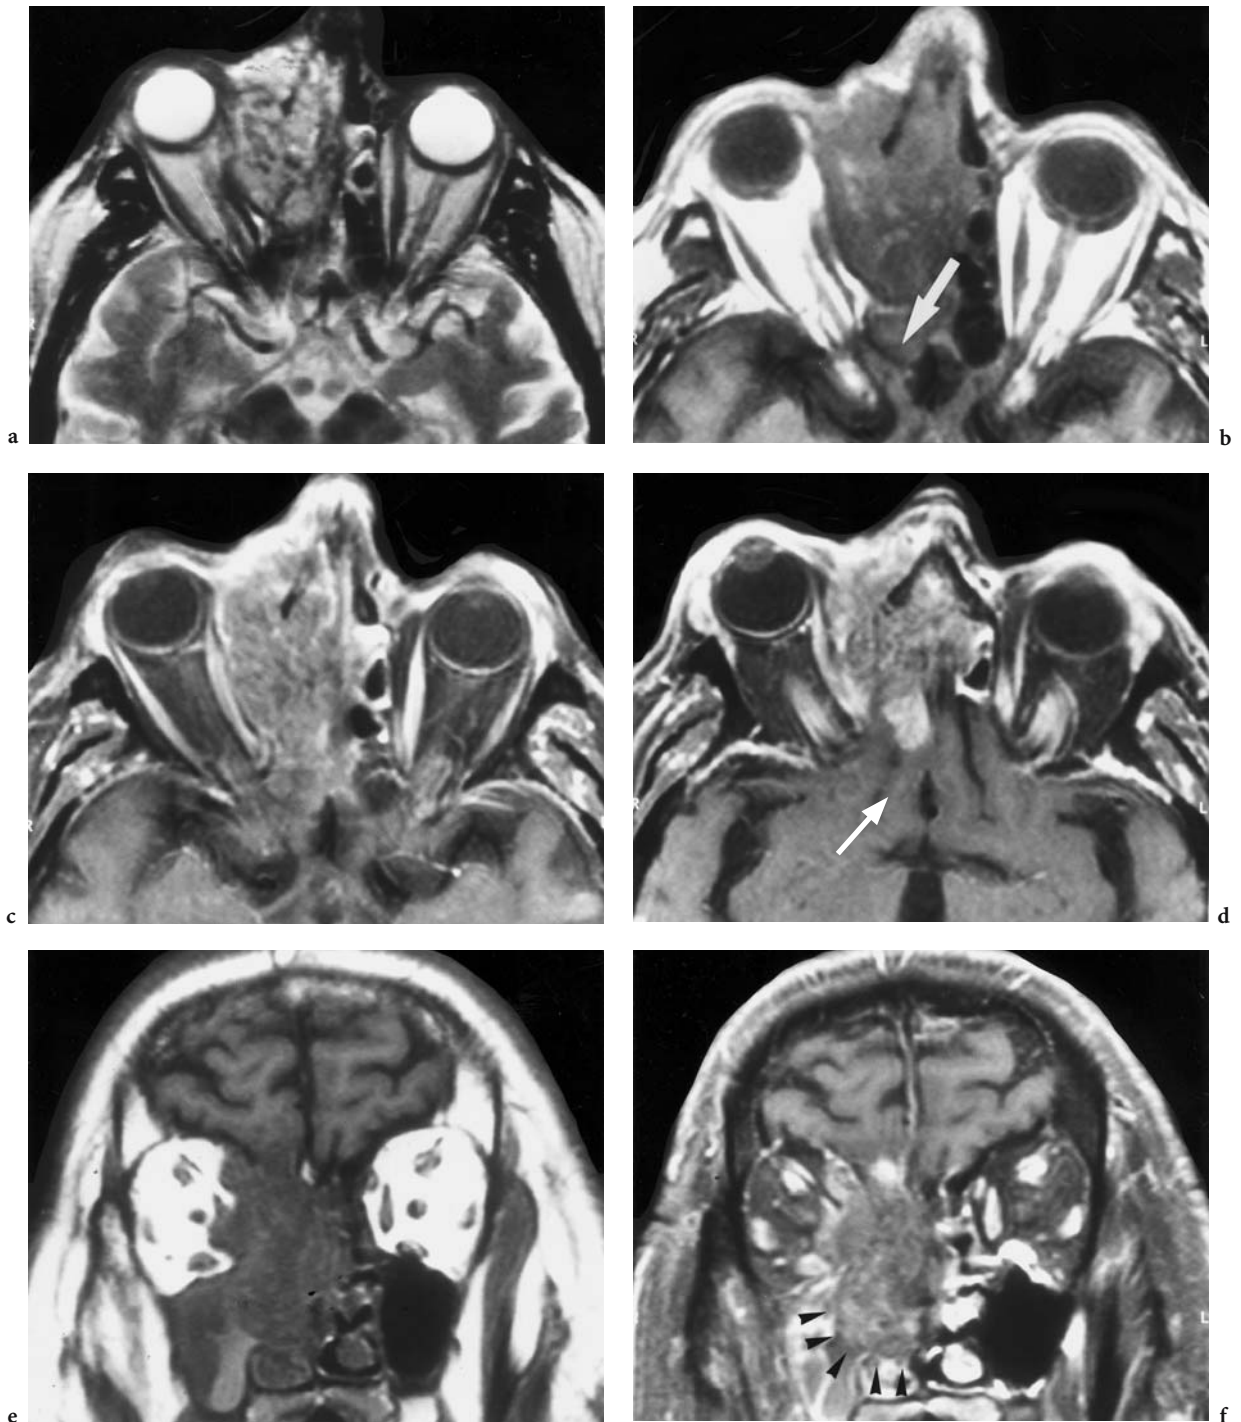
A 60-year-old man with a swollen right eye and history of nasal breathing disability. A nasal tumor was biopsied at an external hospital. Diagnosis: esthesioneuroblastoma. MRI: a Axial T2-weighted image of the medial orbit, demonstrating a tumor invasion of the right medial orbit (with dislocation of the medial rectus muscle), the medial lid, and nasal region by a tumor originating from the right nasal cavity. b Corresponding T1-weighted native view with apparent bony destruction of the entire right lamina papyracea. Note the invasion of the sphenoid sinus and region of the right optic canal (*white arrow*). c Corresponding T1-weighted, contrast-enhanced (FS) view with less marked delineation toward the optic nerve. d Axial, T1-weighted, contrast-enhanced (FS) slice of the upper orbit, demonstrating intracranial tumor invasion (*arrow*). e Coronal T1-weighted native view, showing the entire tumor expansion in the nasal cavity, orbit, and endocranium. Note the inaccurate delineation of orbital and intracranial structures from the tumor. f Corresponding T1-weighted, contrast-enhanced (FS) view, where mainly the intracranial tumor compartment with impression of the right rectus gyrus shows bright signal enhancement. Note the mucous retention in the ipsilateral maxillary sinus; compare with the native view (*arrowheads* demarcate the tumor border)
